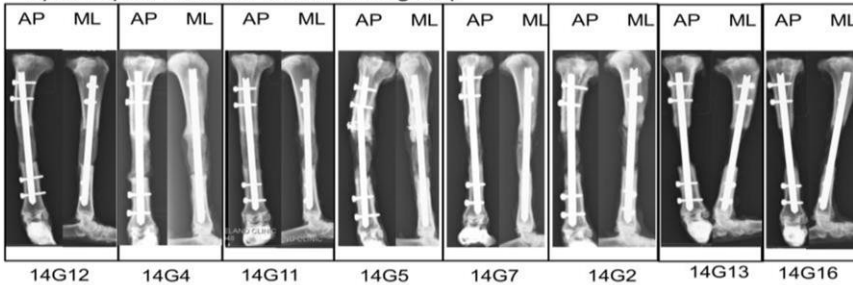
Radiographs taken 12 weeks after grafting with A) unscraped IM; B) scraped IM.
